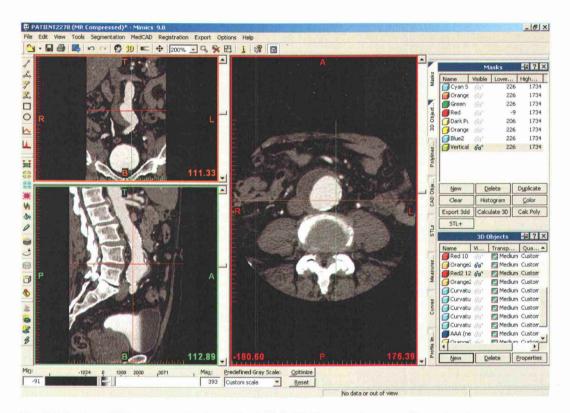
Patient CT image as displayed in *MIMICS*. Gray scale was adjusted prior to application of masks.
